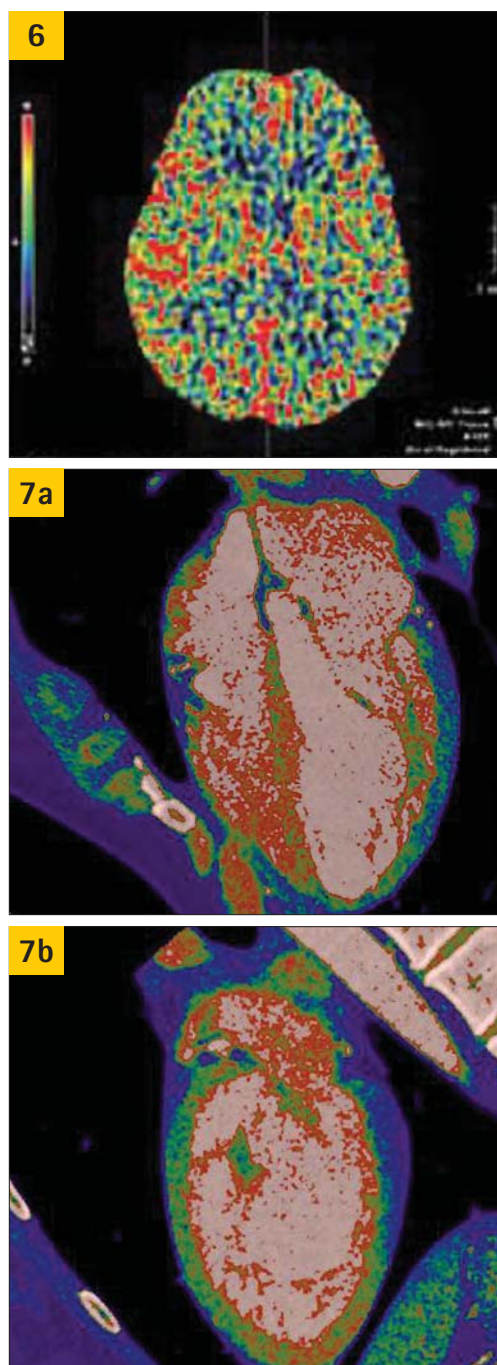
CT maps of brain blood supply
